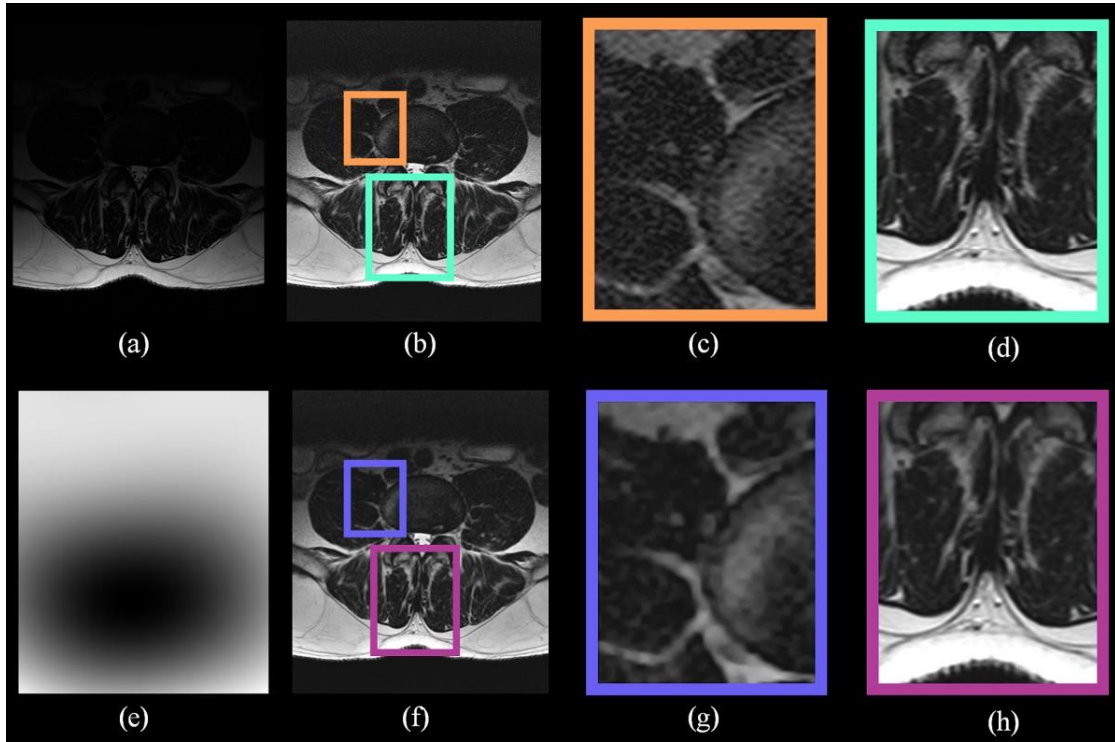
The original MR image (a) and compliment of the extracted bias field (e). Shown are the unbiased image (b) and the unbiased image with bias adaptive NLM (f). Zoomed regions of the unbiased image are shown in (c) and (d), while (g) and (h) are the same zoomed regions for the bias guided filtering. Greater filtering was applied at (g) compared to (h), while little filtering occurred at (d) compared to (h).
